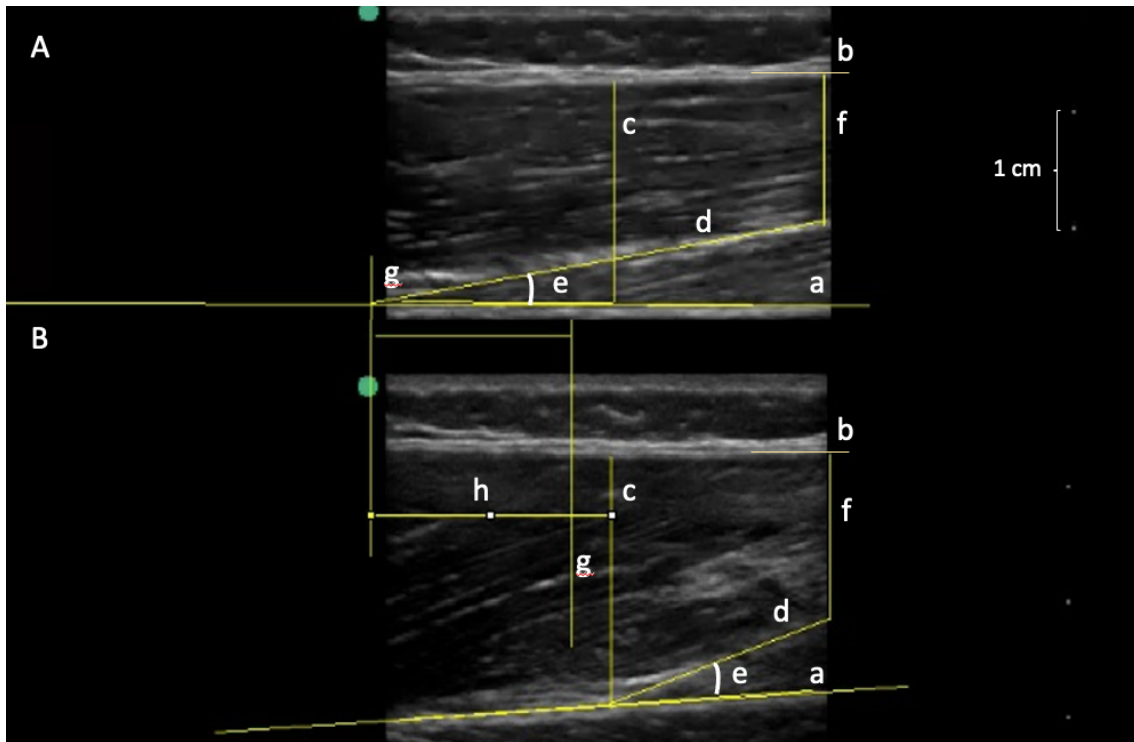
Muscle ultrasonography: An ultrasound analysis of the vastus lateralis at rest (A) and during NMES-evoked contraction (B). (a) deep aponeurosis; (b) superficial aponeurosis; (c) muscle thickness; (d) fascicle with extrapolation or not; (e) pennation angle; (f) distance between end of fascicle visualization and superficial aponeurosis; (g) lines indicating the cross point between fascicle and deep aponeurosis; (h) tendon-aponeurosis complex displacement. Legend: NMES: neuromuscular electrical stimulation.
